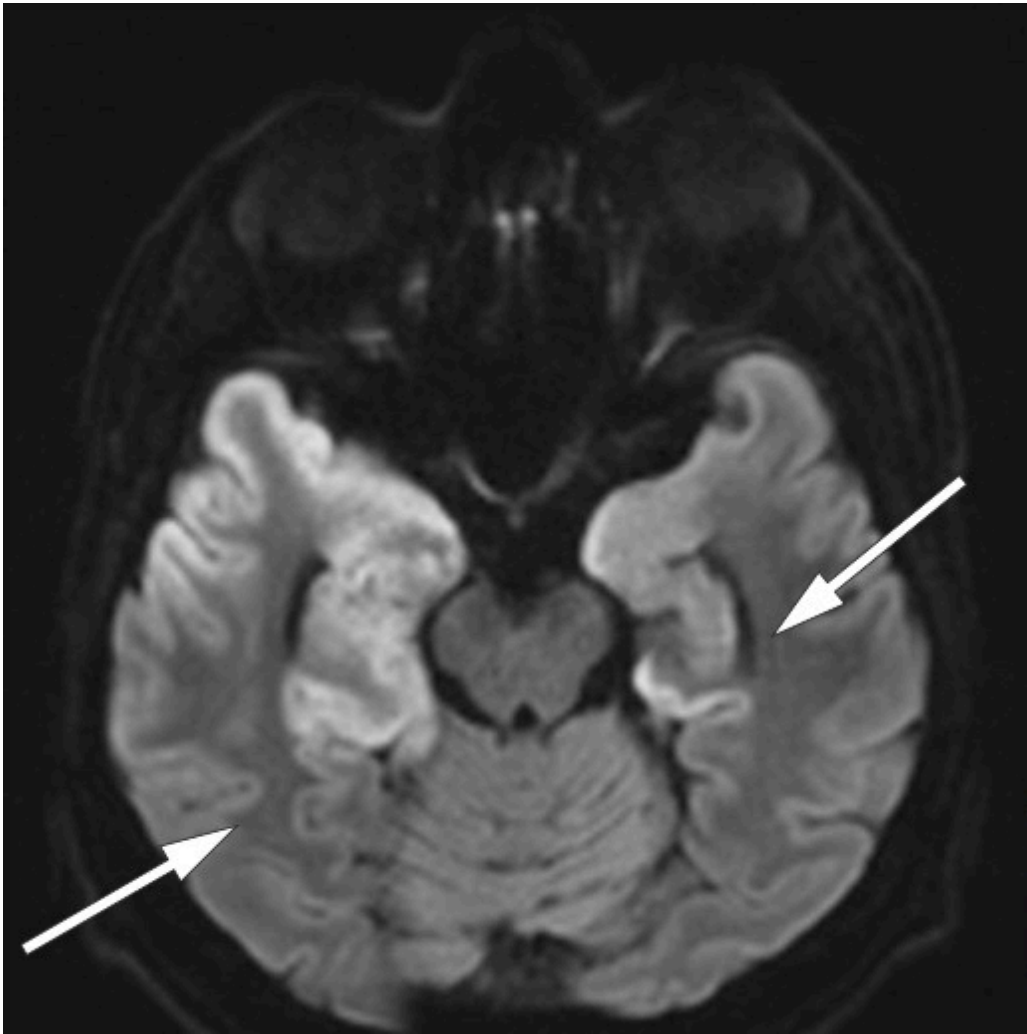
Transverse section of diffusion-weighted MRI six days after admission shows cortical thickening with reduced diffusion (increased signal) in both temporal lobes. Such findings are typical of herpes simplex encephalitis.
